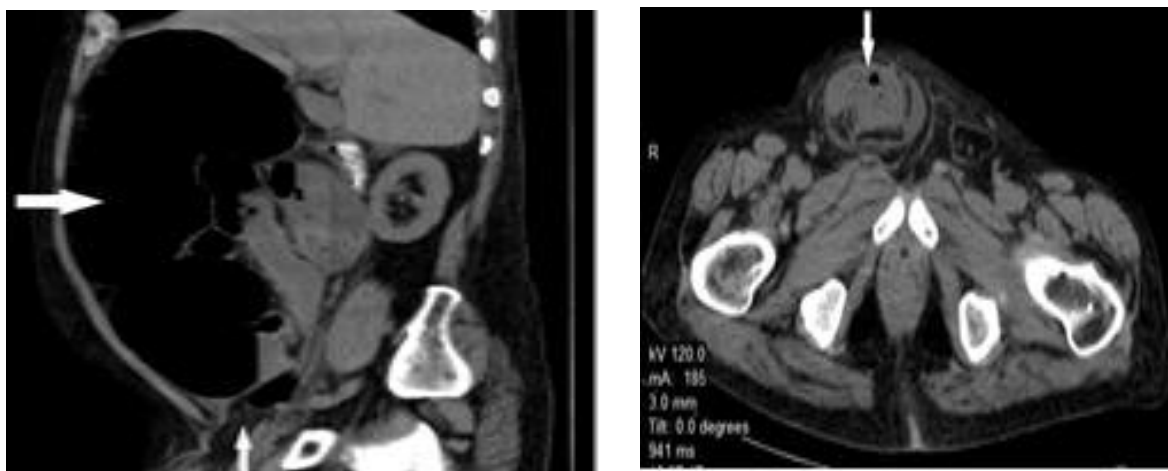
Emergent chest / abdominal CT scan (axial / sagittal views) of a 78-year old woman depicting incarcerated incisional hernia (thick arrow) and strangulated PEH (thin arrow). She underwent emergent gastrectomy (damage-control).
